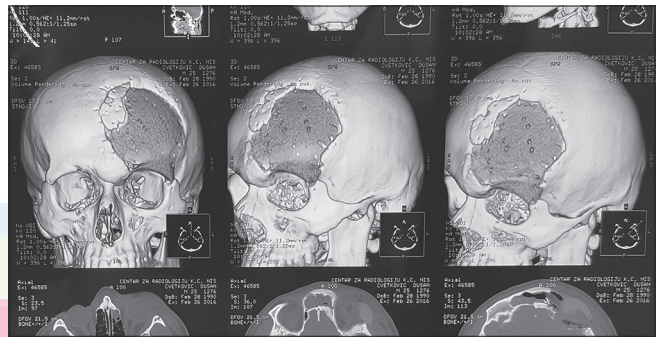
Postoperative computed tomography scan: A patient with reconstruction-polyetheretherketone optima prosthesis
